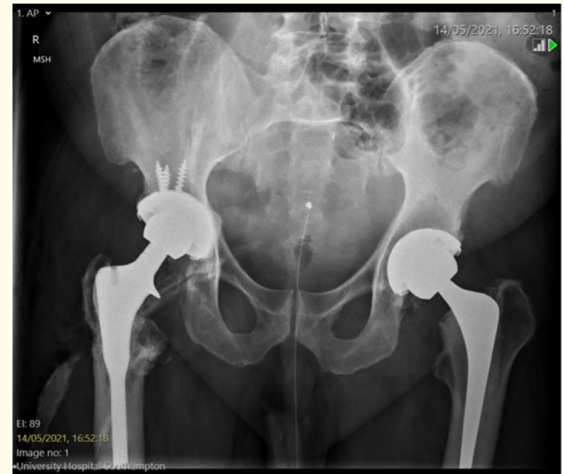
X-ray depicting decreased opacity of shadowing of metallosis.
